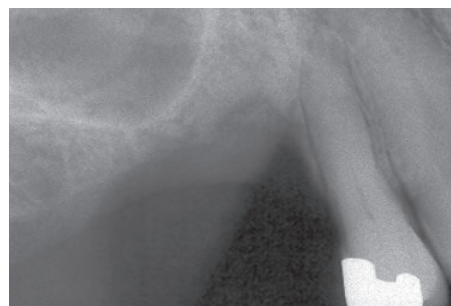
The post-healing radiograph reveals severe ridge resorption in the healed extraction site.
